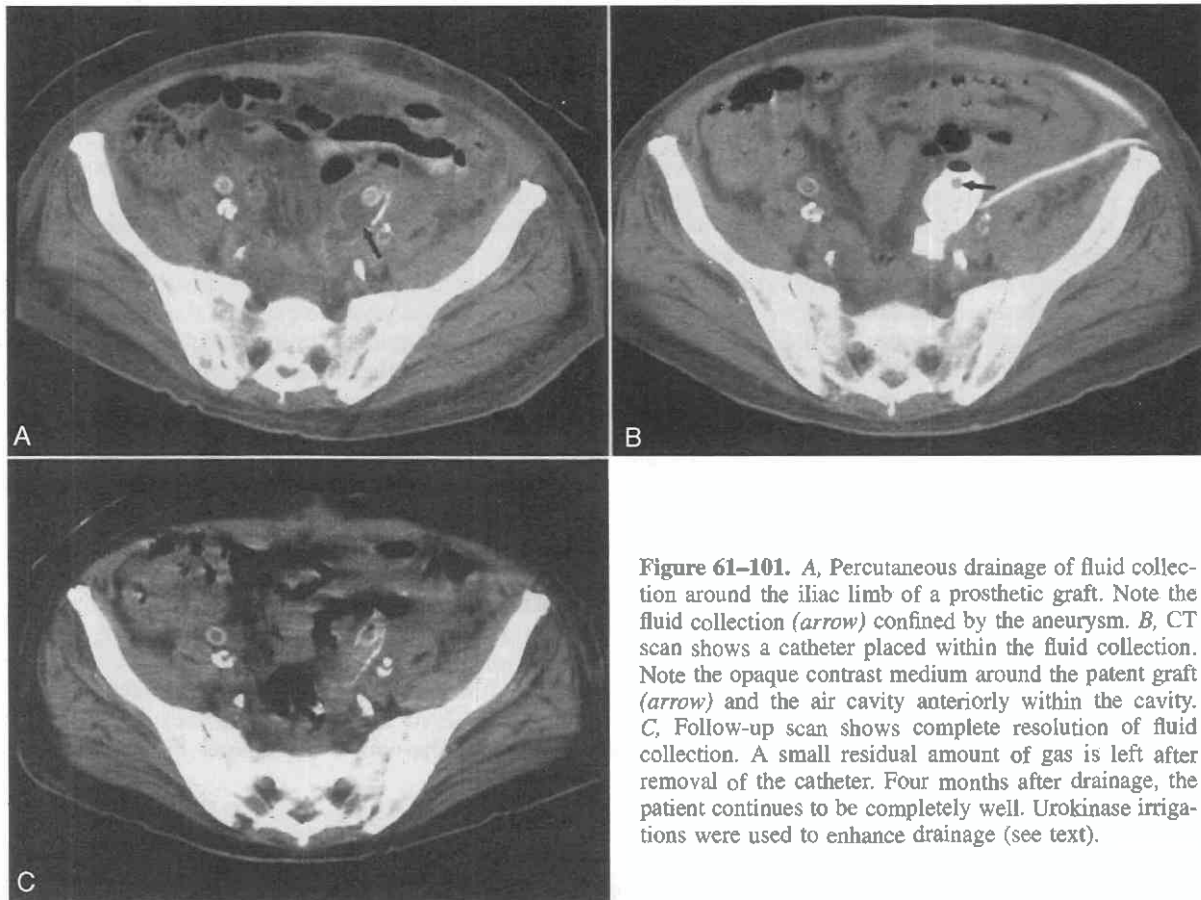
A, Percutaneous drainage of fluid collection around the iliac limb of a prosthetic graft. Note the fluid collection (arrow) confined by the aneurysm. B, CT scan shows a catheter placed within the fluid collection. Note the opaque contrast medium around the patent graft (arrow) and the air cavity anteriorly within the cavity. C, Follow-up scan shows complete resolution of fluid collection. A small residual amount of gas is left after removal of the catheter. Four months after drainage, the patient continues to be completely well. Urokinase irrigations were used to enhance drainage (see text).
